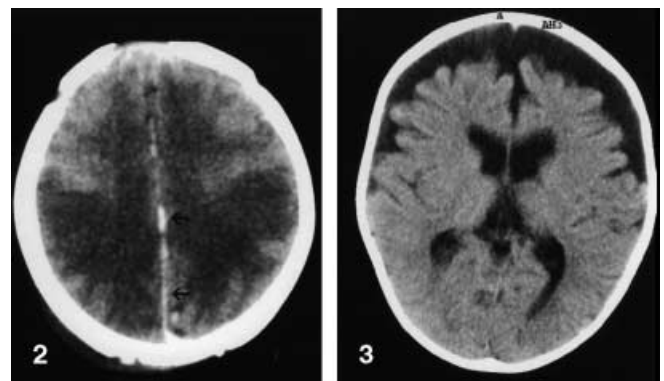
Previous scan of the sibling of one of the patients in this series who had unexplained hydrocephalus. CT on day 1 shows extensive loss of grey-white differentiation and parafalcine blood. Note a cutaneous soft tissue swelling posteriorly (arrows). In retrospect it is most probably NAHI
